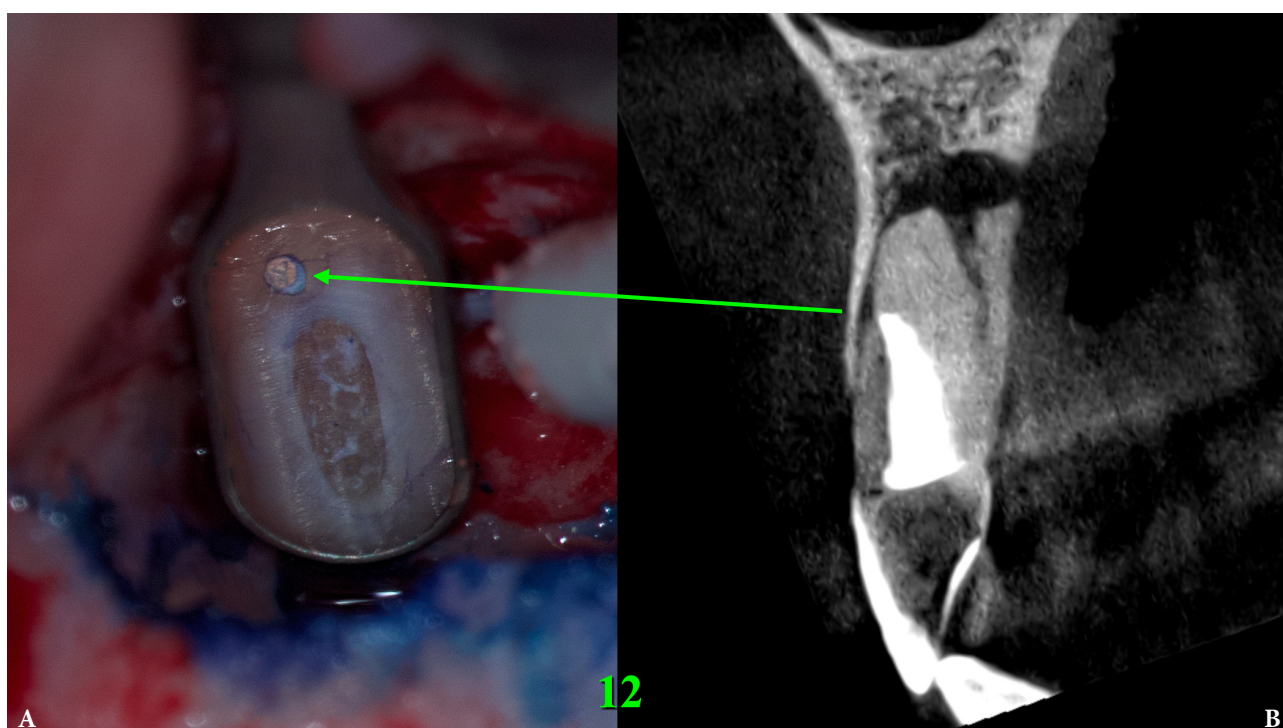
Since there was root canal transportation (*arrow*) (A) with perforation of the vestibular wall of the root in the area of the tooth 12 which was manifested by slight radiolucency in this place on a sagittal CBCT scan (B), a decision was made to perform a resection of the surface of this root by another 0.5 mm so that there was access to transportation with the possibility of making a retrograde preparation. 12, upper right lateral incisor.
